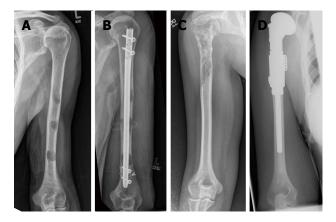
Different fixation methods for metastases of the humerus. A, B: Show the pre and post-operative X-rays of a 71-year-old male with painful metastatic lesions secondary to renal cell carcinoma. The humerus was stabilized using a locked intramedullary nail with a prophylactic distal cerclage wire, excellent pain relief was achieved; C, D: Show the pre and post-operative status of a 40-year-old female with painful metastatic breast carcinoma. The painful lesion was excised and replaced with an endoprostheses, good symptomatic relief was achieved.
